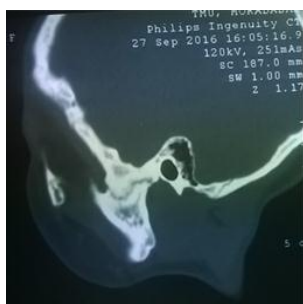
Sagittal section of CT showing union of left TMJ
